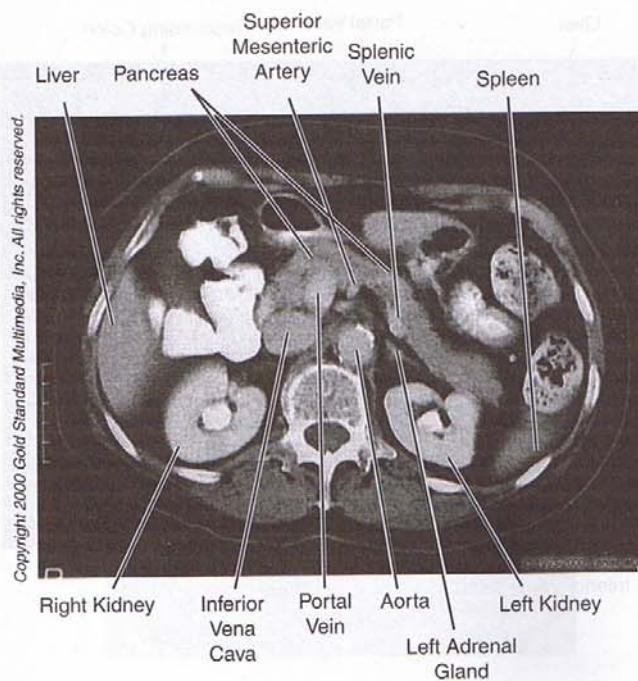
Abdomen: CT, L₁
